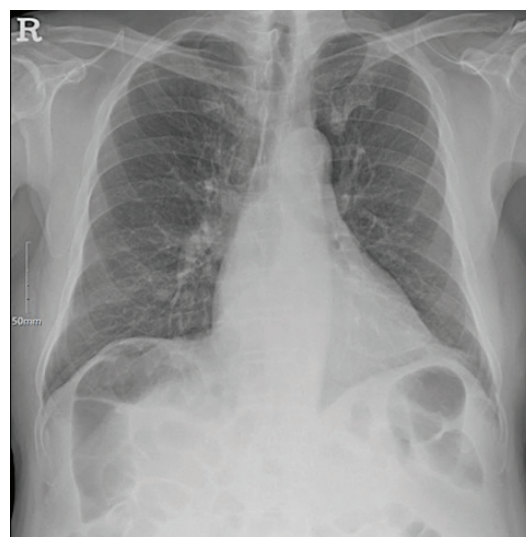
Chest X-ray; normal
